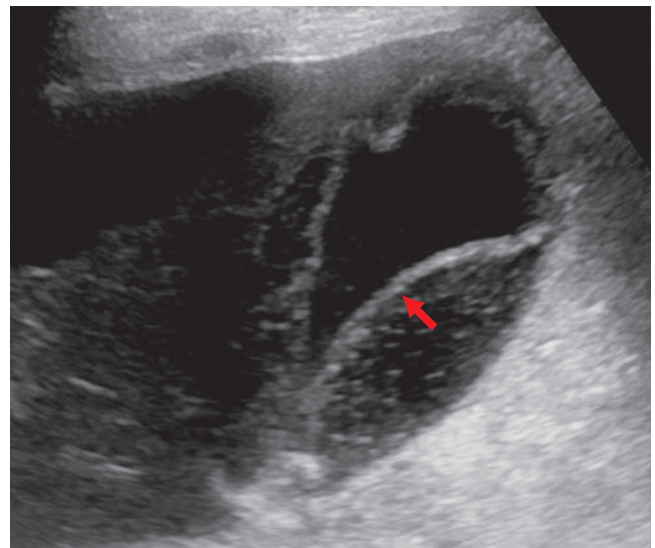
The sagittal sonographic image of the gallbladder again shows intraluminal membranes that are parallel to the gallbladder wall (arrow) indicative of sloughed mucosa.
